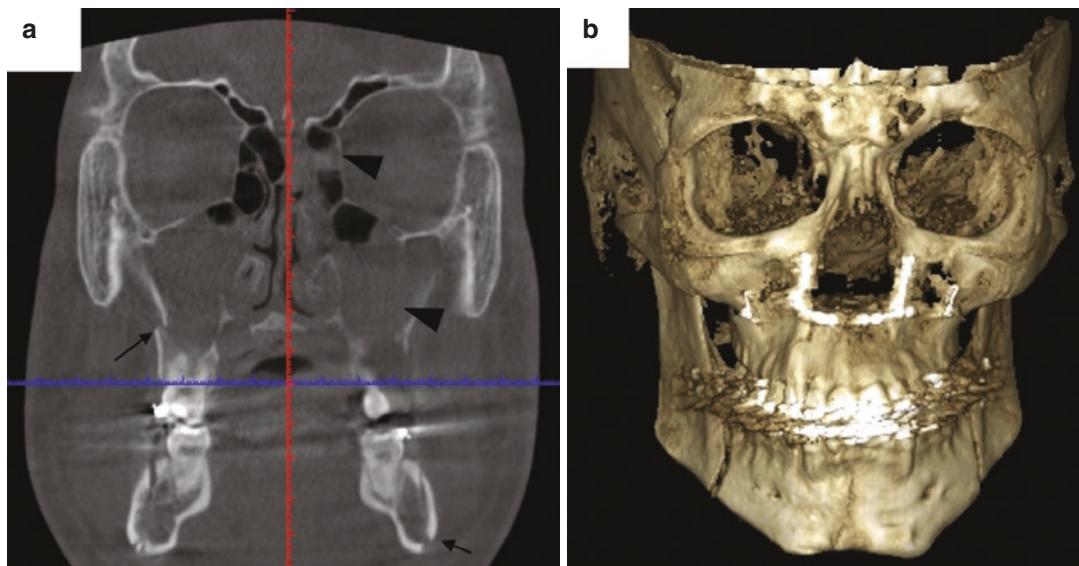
(a) Large field-of-view CBCT coronal image (a) and a 3-D view (b). Changes after the orthognathic surgery are seen. Images show disruption of the bone due to
